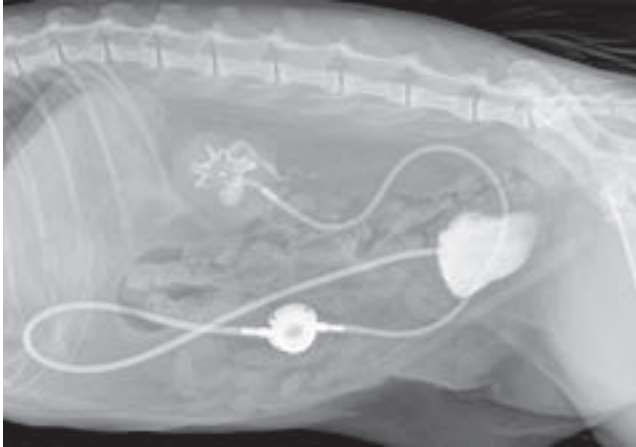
Post-operative lateral abdominal radiograph demonstrating contrast filling the SUB system. Image courtesy: Claire Deroy.
